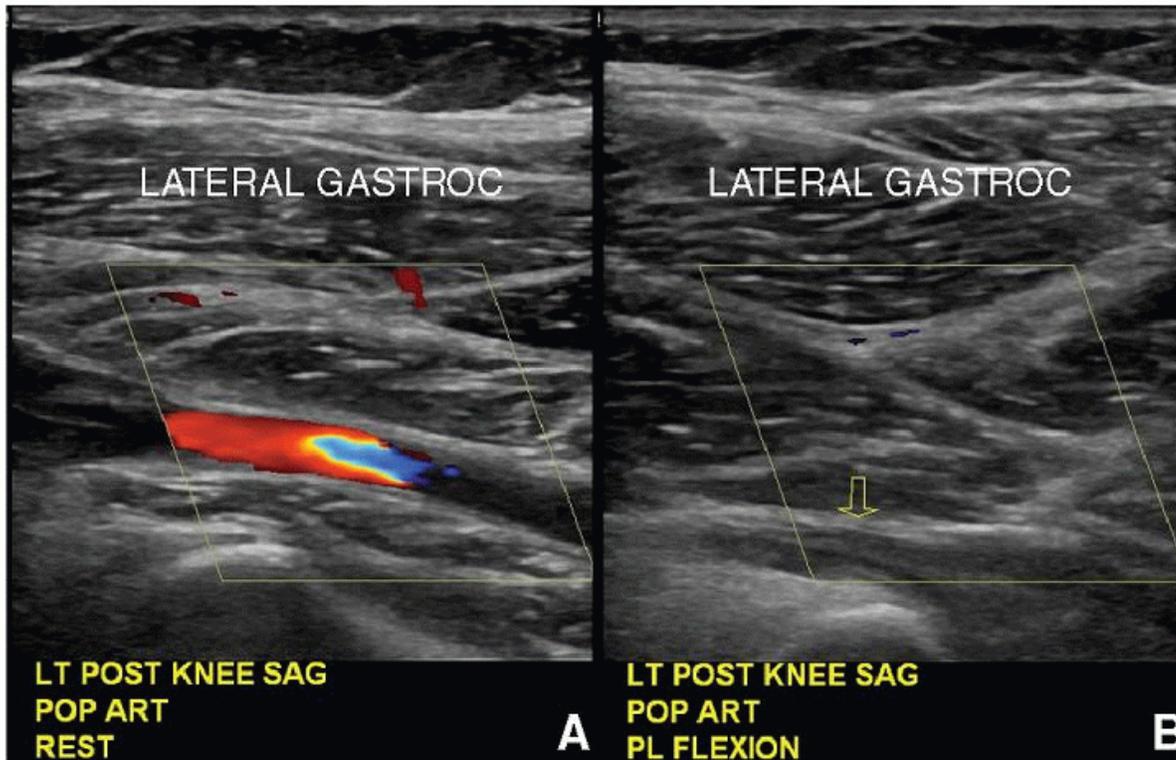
Color Doppler images demonstrating PAES. A: Color Doppler flow is seen in the popliteal artery at the level of the tibial plateau at rest. B: No flow is seen in the popliteal artery during resisted plantar flexion.
